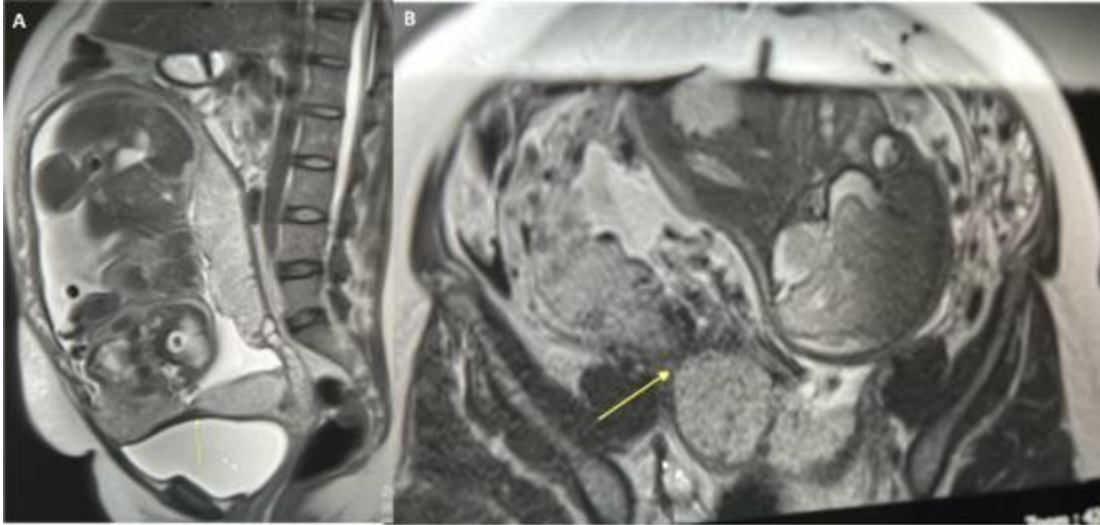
MRI showing placenta previa accrete.
